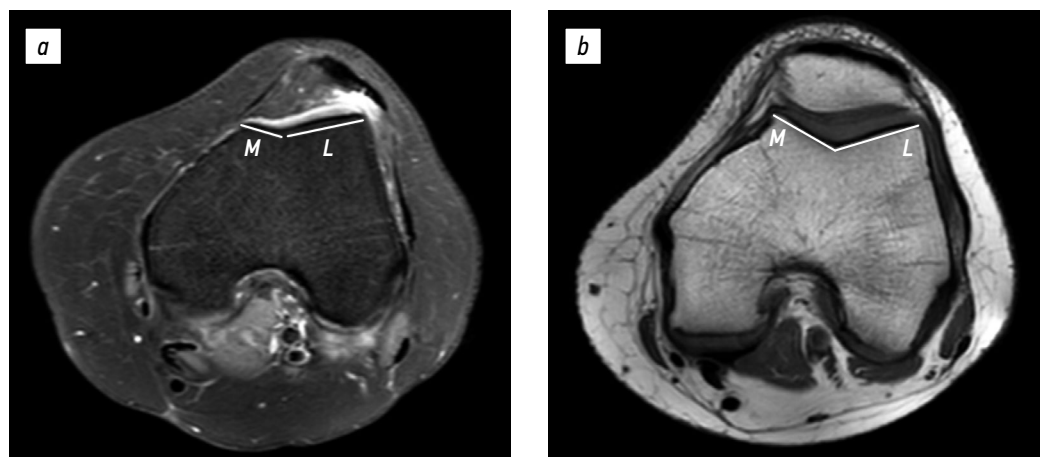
Trochlear facet asymmetry index on magnetic resonance imaging: (a) 16-year-old female patient with patellar instability (33%) and (b) 17-year-old female patient with anterior cruciate ligament injury (75%). M, medial facet length; L, lateral facet length.
